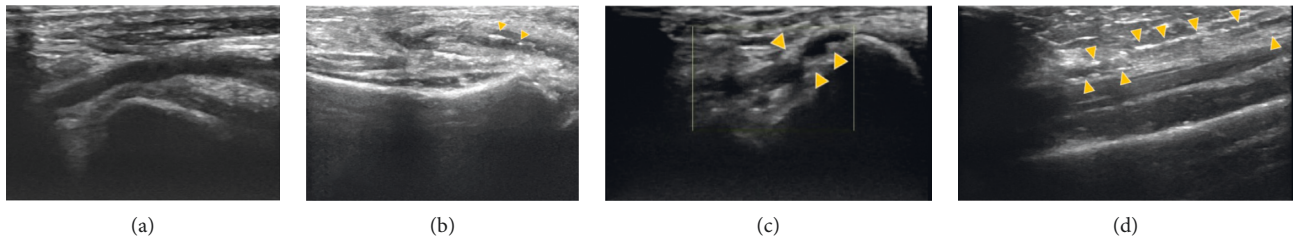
Ultrasound scanning of the distal radial artery, showing normal aspect (a) and calcific deposits within the vessel wall (yellow arrows), organized as calcific nodules (b), calcific plaques (c), and diffuse medial calcinosis (d).
